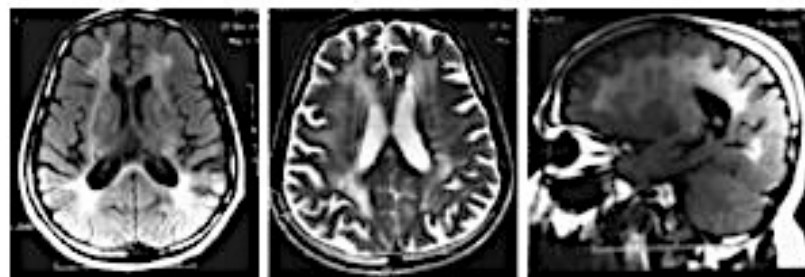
(left) Axial T1-weighted (T1WI) MRI. (right) Axial T2-weighted MRI showing leukoencephalopathy in the periventricular, deep hemispheric, centrum semiovale, temporo-parietal and external and internal capsular areas. Similar signal abnormality also involved the corpus callosum. Multifocal infarctions of varying sizes and shapes were also seen within the abnormal areas as well as in the left side of the pons.
